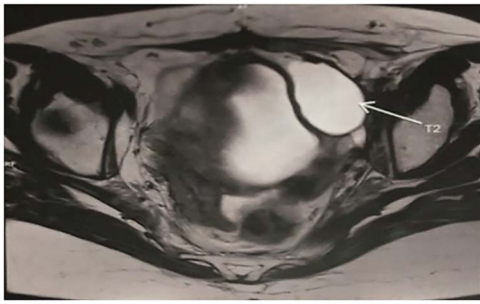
Pelvic MRI objectified presence of oval formation at the left posterolateral vaginal wall measuring 19/9 mm (axial T2-weighted image).
